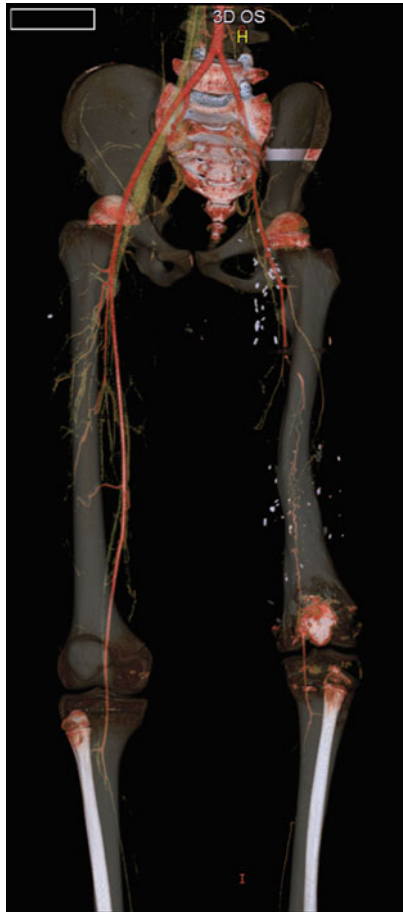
CT angiography – long segmental vascular defect of superficial femoral artery
